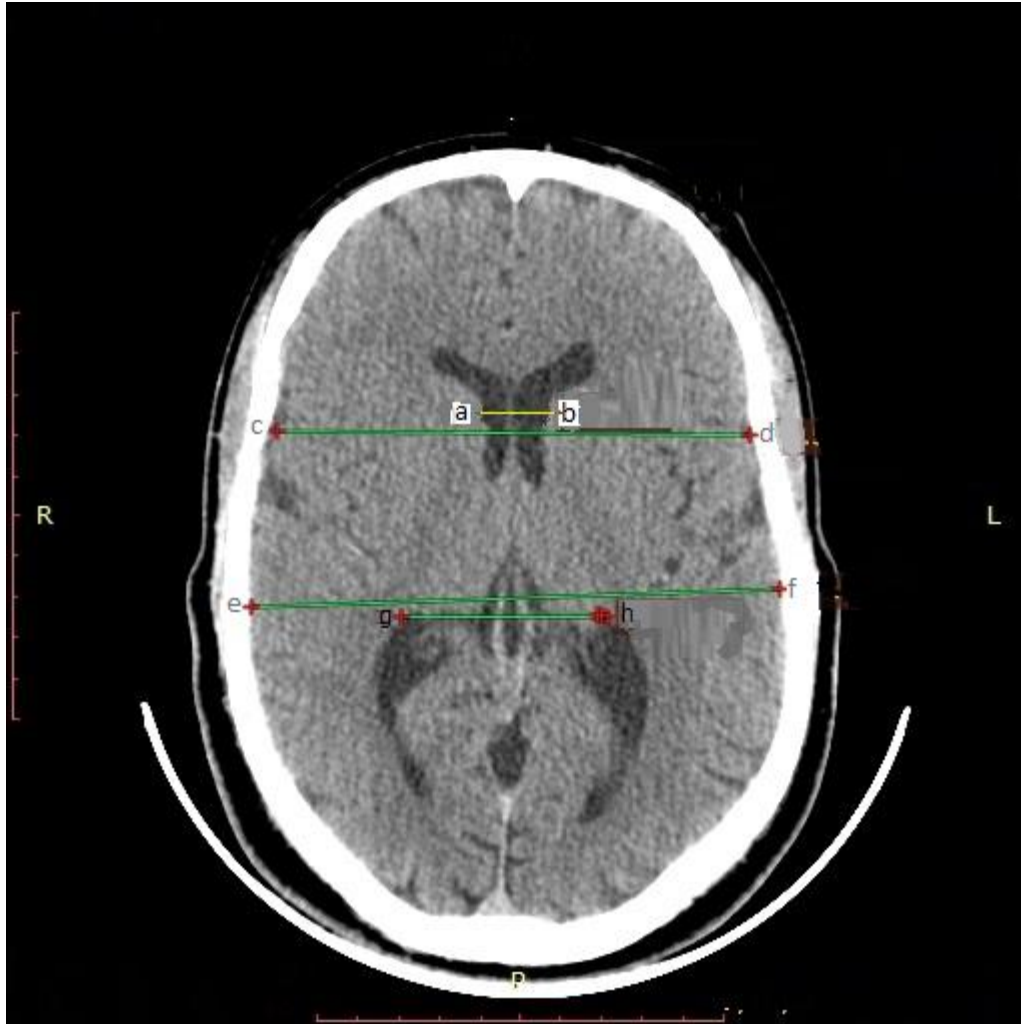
A CT showing measurement Bi-Frontal Index (BFI); determined by the ratio of the measured distance between the lateral borders of the frontal horns (a-b) and the transverse intracranial diameter (c-d) at the same level. Similarly, the Bi-Occipital Index (BOI) was determined by the ratio of the measured distance between the most lateral borders of the occipital horns (g-h) and the transverse intracranial diameter at the same level (e-f).
